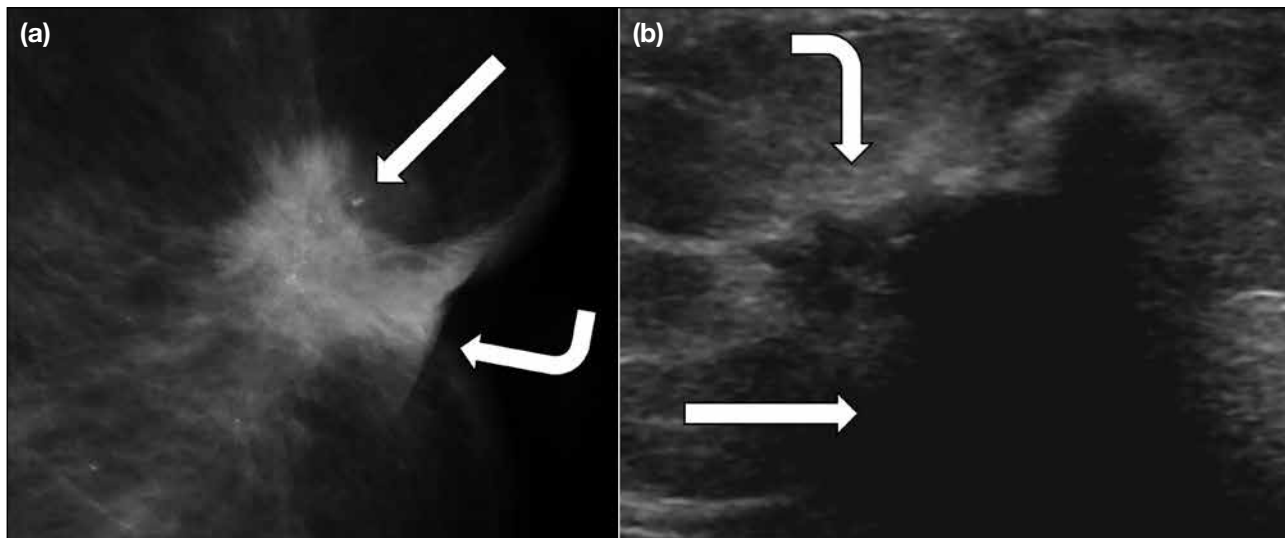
True discordance. An irregular high-density mass showing spiculated margins was noted to have fine pleomorphic calcifications (straight arrow) and architectural distortion in magnified craniocaudal view on mammogram (a). Associated skin and nipple retraction (curved arrow) was noted. Ultrasound of the mass (b) also showed suspicious features, including irregular shape, spiculated margin, significant posterior shadowing (straight arrow), and echogenic halo (curved arrow). The lesion was classified as Breast Imaging Reporting and Data System category 5 lesion. Ultrasound-guided biopsy of the mass was performed and the initial pathological diagnosis of fibrofatty tissue was considered discordant with the imaging findings. On repeat ultrasound-guided biopsy, the diagnosis of invasive ductal carcinoma was made.
